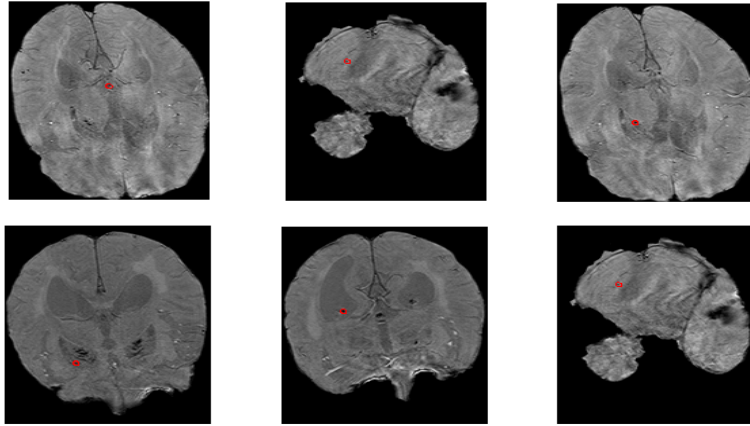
Some results of false-positives in T2* MRI images. The red circles indicate the location of the FPs.
